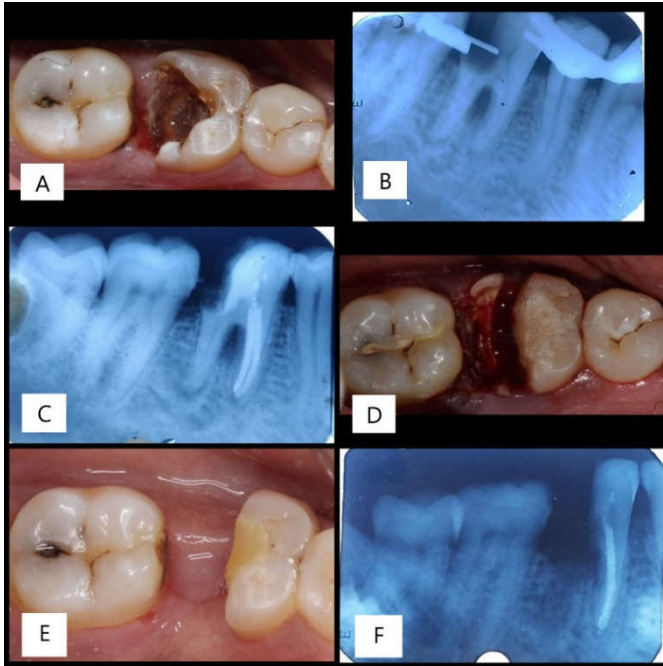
A – Pre-operative Clinical Photograph, B – Pre-operative radiographic view C – Post-obturation of mesial canals, D – Hemisection, E – Healing after 2 months, F – Radiograph after 2 months
